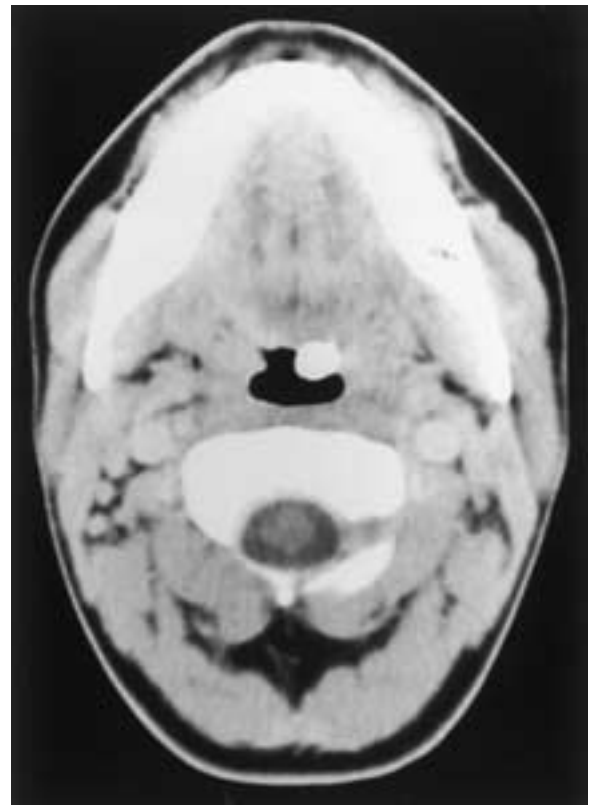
Lingual osteoma. Axial CT scan shows a bone density mass near the midline of the base of the tongue.
